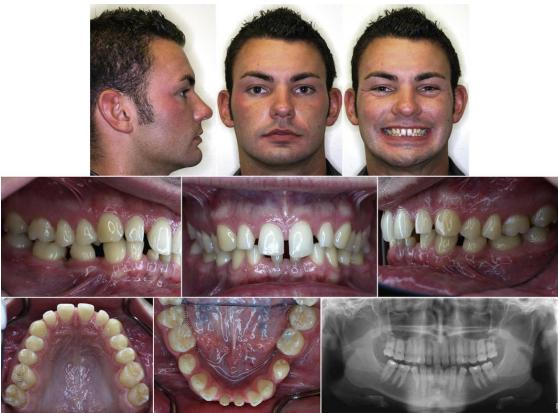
Pretreatment extraoral/intraoral photographs and panoramic radiograph.
